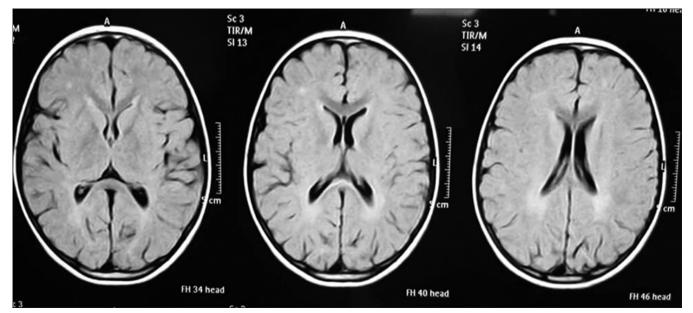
Magnetic resonance imaging brain performed using a dedicated head coil on a 1.5 tesla scanner, the fluid-attenuated inversion recovery images revealed bilateral cerebral hemisphere periventricular deep white matter high signal intensity going with periventricular leukomalacia with right frontal subcortical lacunar gliosis
